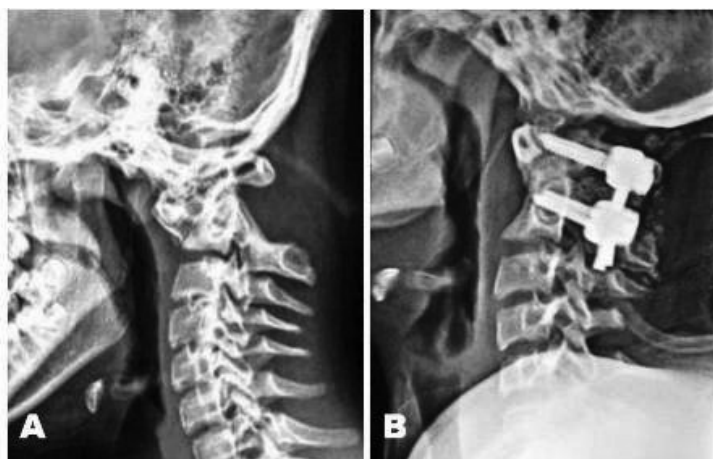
(A) Plain X-ray film of the cervical spine (lateral view) in a 13-year-old female Down patient showing atlantoaxial instability (B). Immediate postoperative X-ray film (lateral view) showing sound fixation and good reduction of C1-2 (B).
